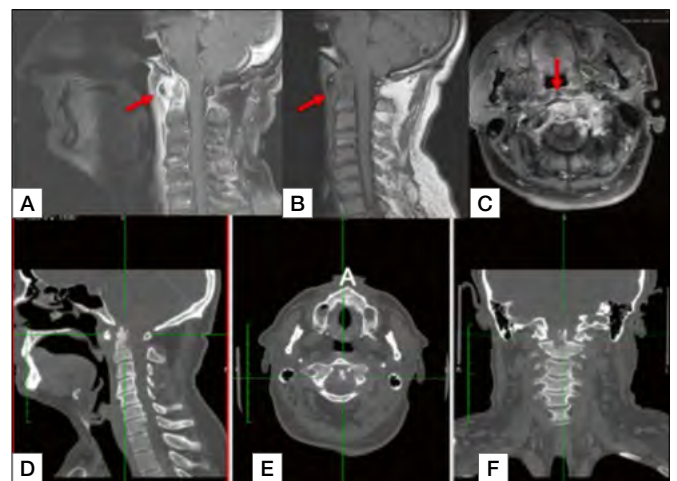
Use of navigation system to perform a biopsy of a lesion (arrow) of the odontoid on sagittal and axial MRI (A, B, C). Intraoperative view with CT scan (D, E, F) The cross-air revealed a correct target reached through a minimally invasive EEA. The biopsy revealed a localization of myeloma.
